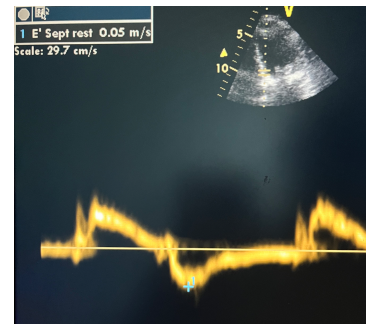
Representative views of transthoracic echocardiography
